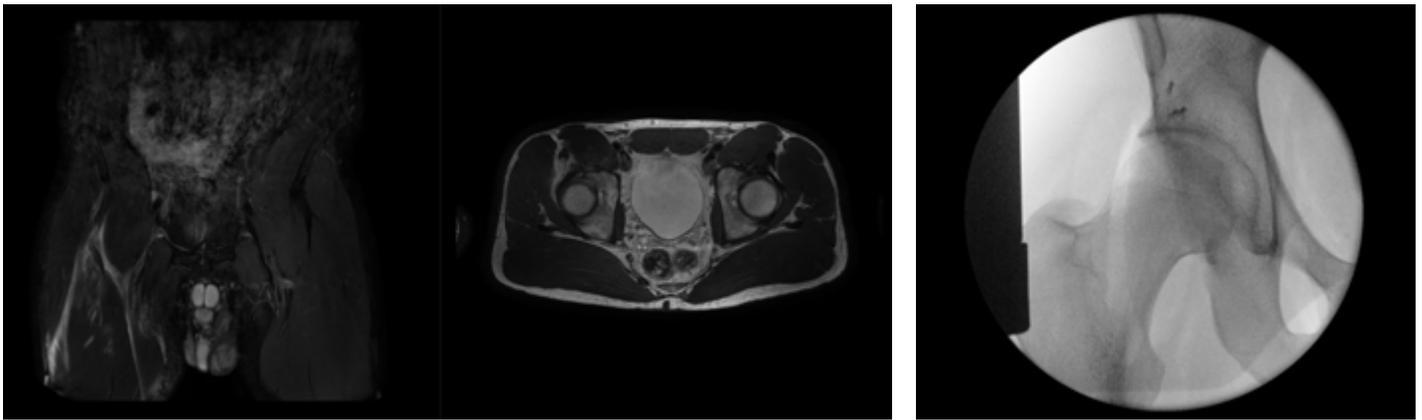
Coronal and axial MRI demonstrating proximal rectus femoris tendon avulsion on the right side (left), and radiographic evaluation of correct positioning of suture anchors follow surgical repair (right).
